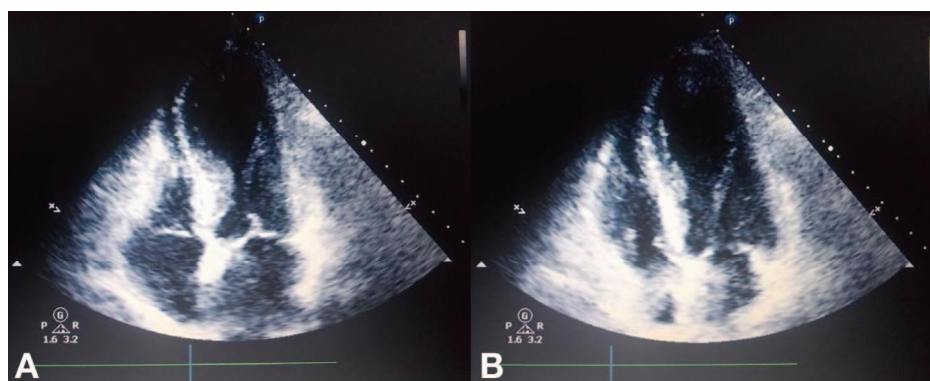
Transthoracic echocardiogram (apical 4-chamber view) 5 days after subarachnoid hemorrhage attack showing apical hypokinesia and basal sparing of left ventricle in systole (A) and in diastole (B).
